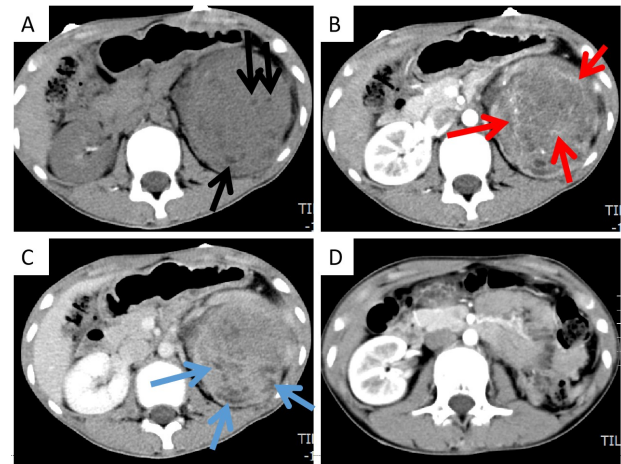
A. CT scan revealed a large soft tissue mass with uneven density in the left renal region, and nodules and patchy low-density shadows (black arrows). B. In the cortical stage of enhanced scanning, the lesion was slightly inhomogeneous in enhancement, and the septom-like enhancement shadow was visible in it (red arrow). C. Contrast enhanced CT in the medullary phase of the lesion continued to non-uniform enhancement, the tumor surrounding a number of small nodular cystic lesions with no enhancement. (black arrow). D. After nephrectomy, the left renal fossa was occupied by intestinal tissue.
